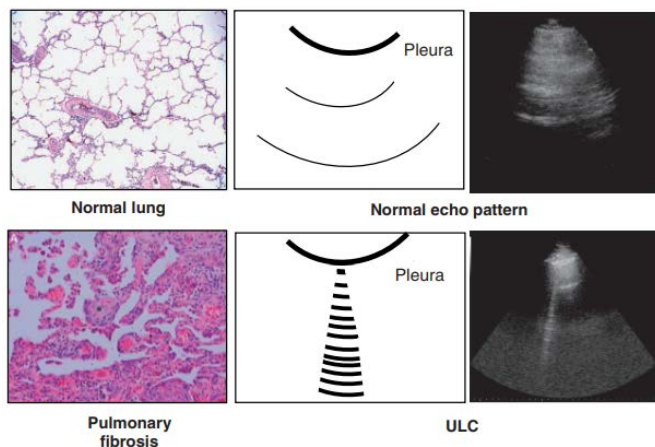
Reflections of the ultrasound beam by thickened interlobular septa give rise to ULCs.
